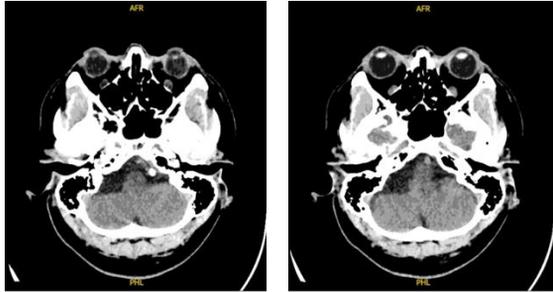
CT scan showing right cerebellomedullary hypodensity
